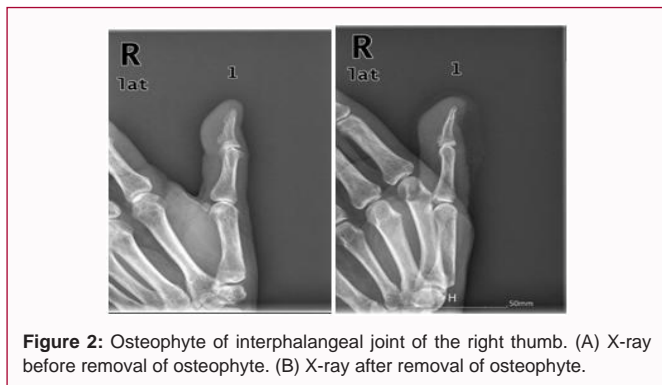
Osteophyte of interphalangeal joint of the right thumb. (A) X-ray before removal of osteophyte. (B) X-ray after removal of osteophyte.
